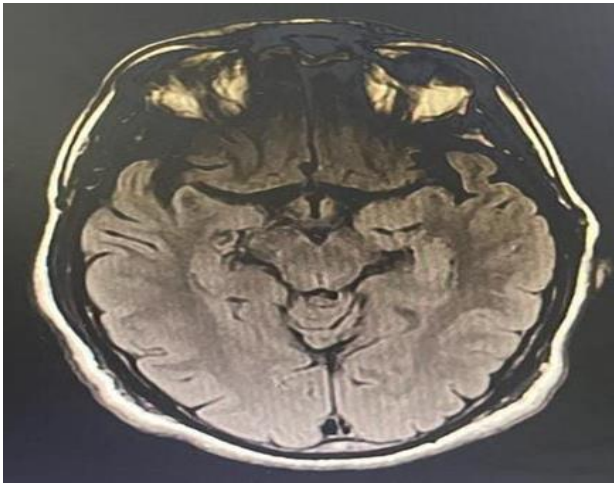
MRI brain showing enlarged left hippocampus with ill defined gyriform pattern of diffusion high signal and low ADC showing T2/FLAIR hyperintensity. Increased perfusion in ASL images noted in the region- possibility of post ictal edema. Discrete FLAIR hyperintensities in bilateral frontal white matter-small vessel ischemic changes
